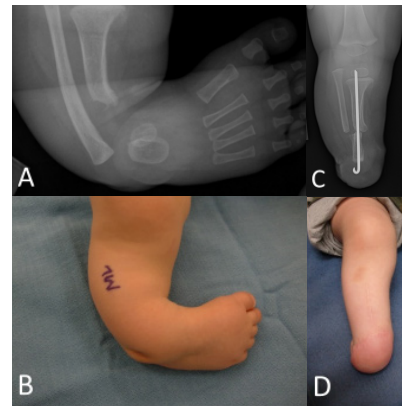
Incomplete tibial hemimelia with club-type foot deformity. A. X-ray. B. Clinical appearance. C. X-ray after Syme amputation of the foot and tibia-fibula synostosis. D. Clinical appearance postoperatively. The hindfoot was sectioned in the coronal plane. There was a complete subtalar synchondrosis.
